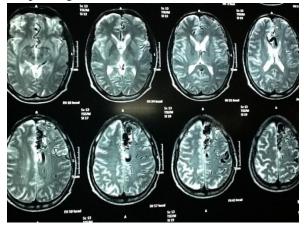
T2 FLAIR: Multiple flow voids in left parasagittal frontal lobe.
